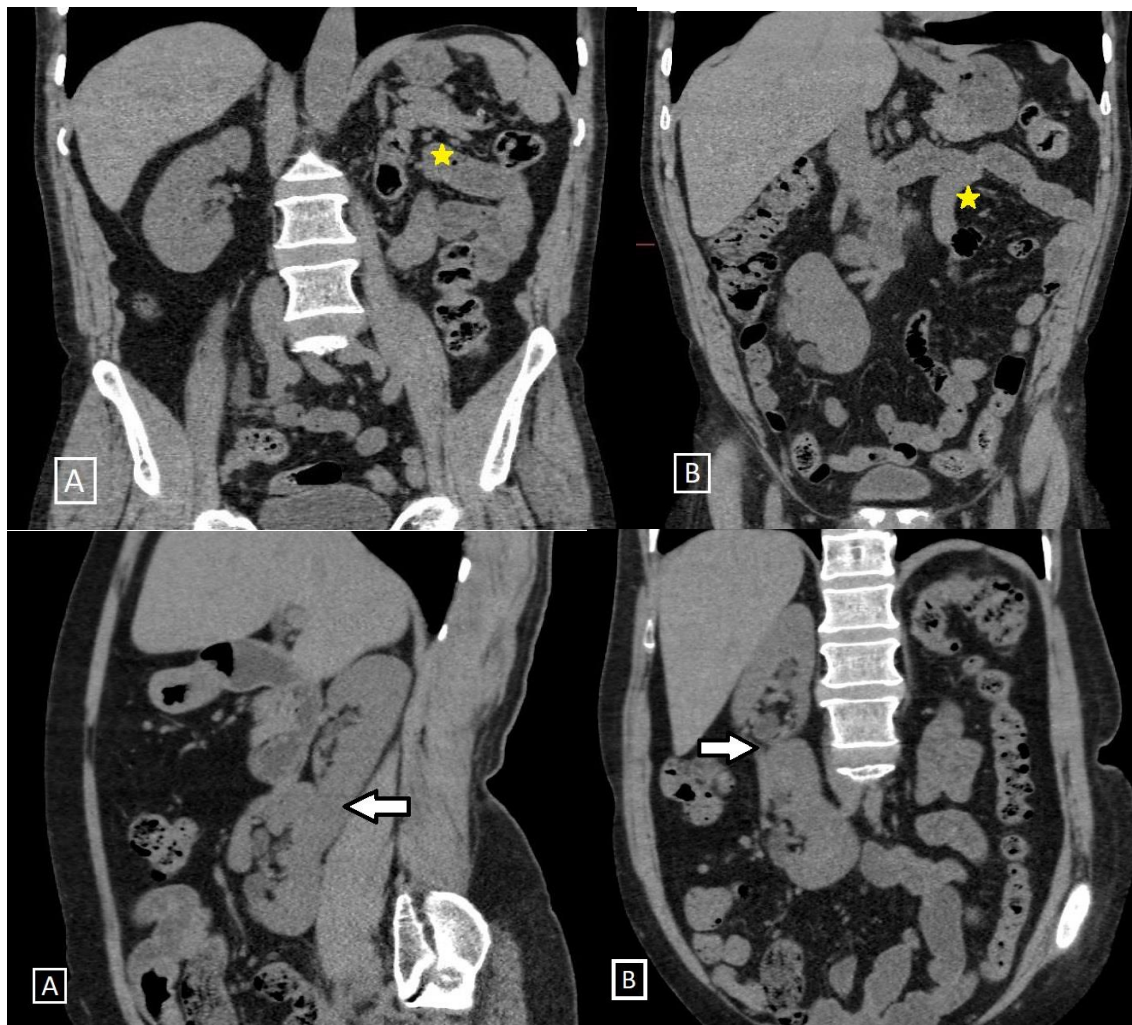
Plain CT coronal reformatted sections (A, B) showing empty left renal fossa. Two kidneys seen separately on the right side. Sagittal and coronal reformatted sections (C, D) of a different patient shows empty left renal fossa. Two kidneys seen on the right side with fusion of the lower pole of the upper kidney with the upper pole of the lower kidney (white arrow).
